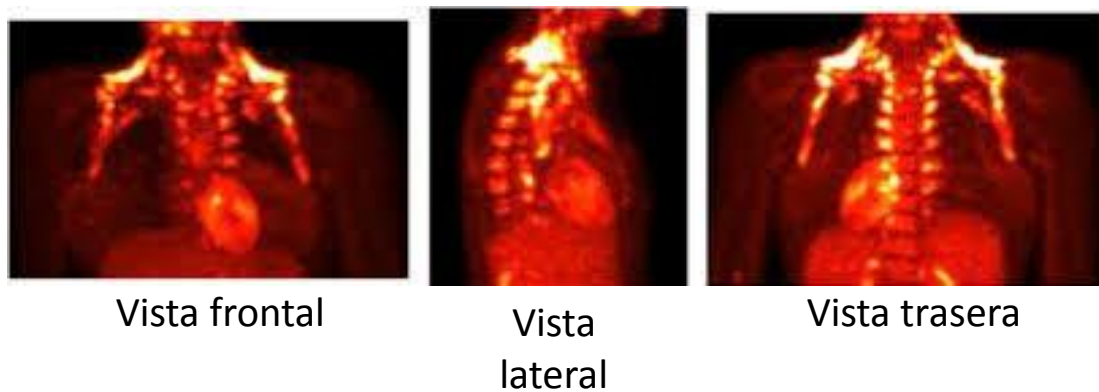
Activación metabólica del BAT supraclavicular. En adultos se analizó la activación del BAT mediante tomografía por emisión de positrones (PET) combinada con tomografía computarizada (CT), previa administración al paciente del trazador ^{18}F -fluorodesoxiglucosa (^{18}F -FDG). Se observó una mayor captación de glucosa en la región supraclavicular (mayor brillo en la imagen) correspondiente al BAT (Adaptado de Virtanen, 2016).
